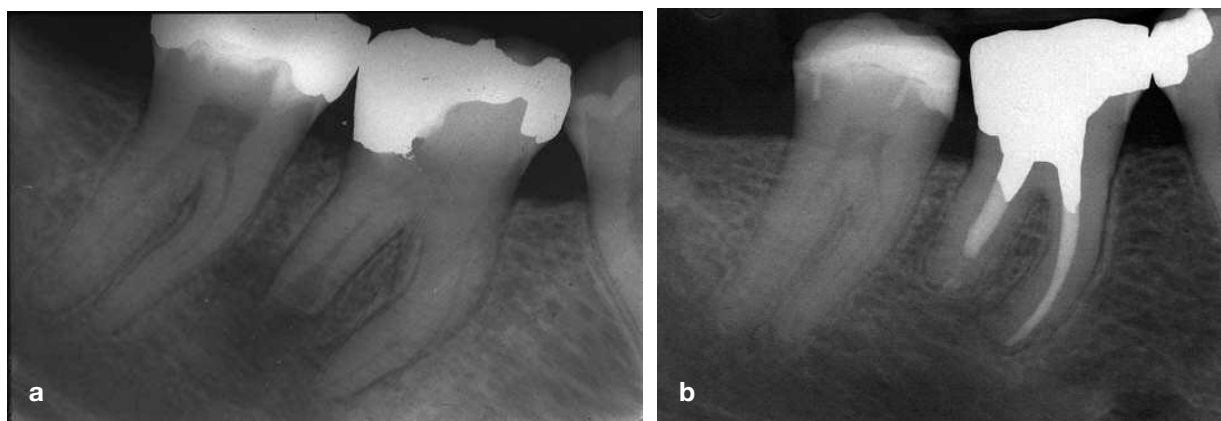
(a) Pre-operative radiograph of a heavily restored lower right first molar with significant apical inflammatory root resorption and chronic apical periodontitis. (b) 15-year review following orthograde endodontic treatment and full coverage amalgam overlay restoration.
